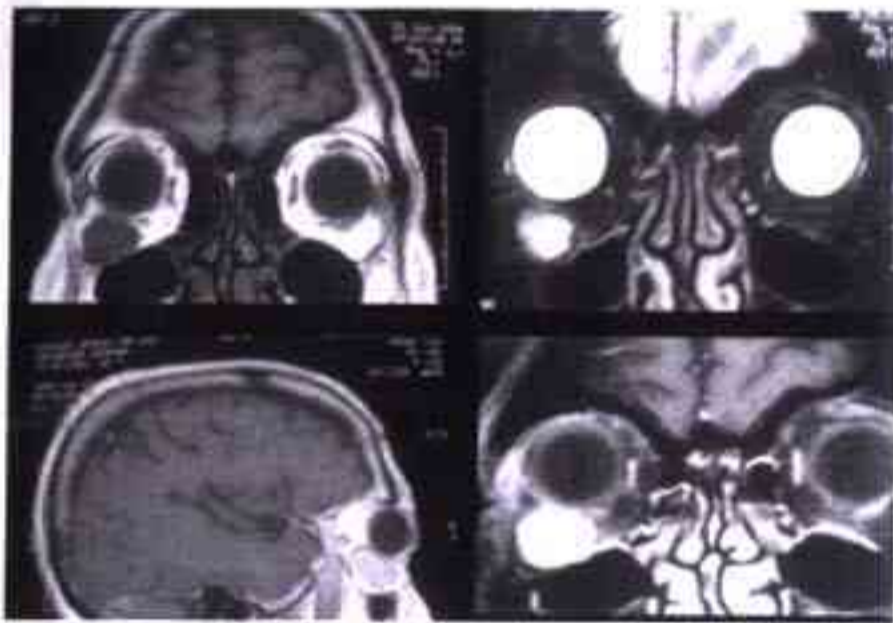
MRI showing isointense signal on T1 weighted images and hyperintense signal on T2 weighted images with moderate contrast enhancement
